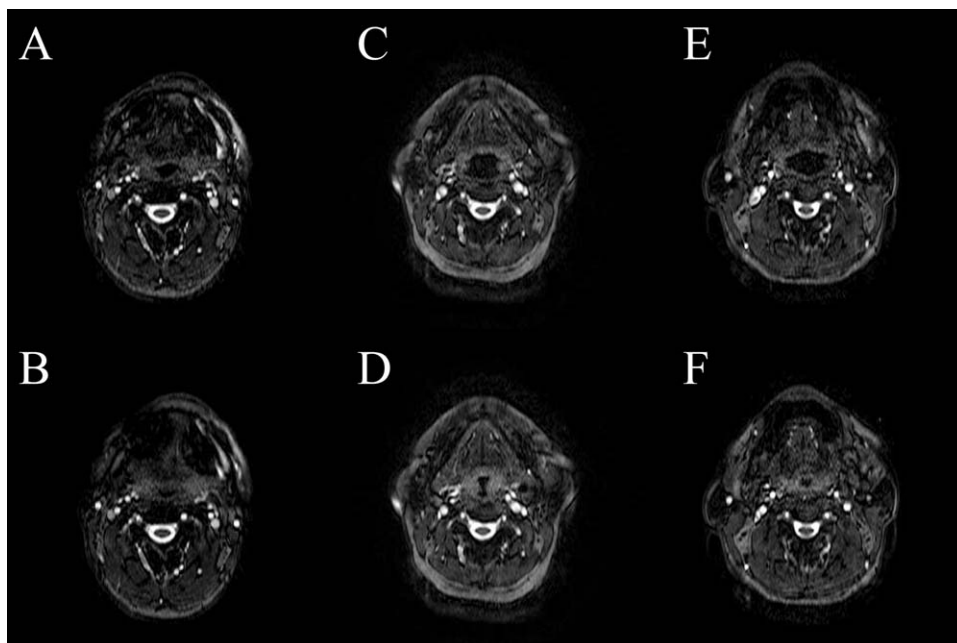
Axial magnetic resonance images at the retrolingual level of representative anteroposterior collapse (A, B), transverse collapse (C, D), and circumferential collapse (E, F).
